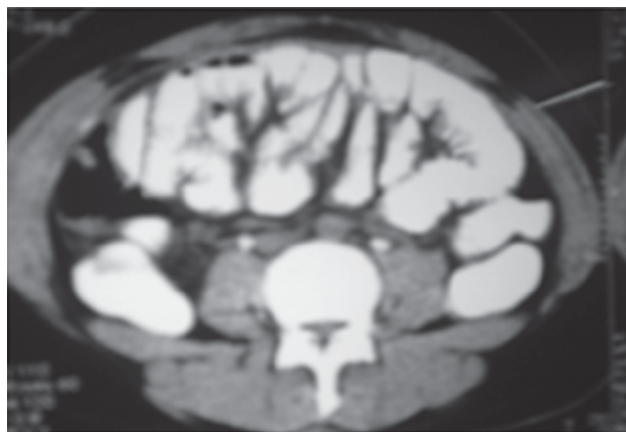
CT scan of Abdomen showing small gut loops closely packed in a capsule.
